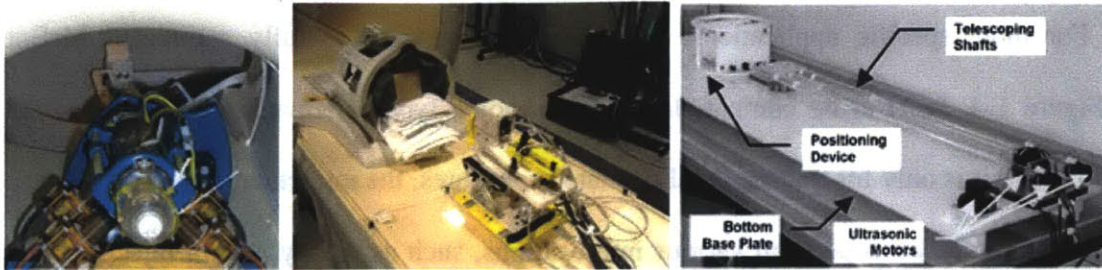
MRI compatible robots designed for single probe placement. Left: Mr. Bot from John Hopkins contains interchangeable end effector, allowing it to perform various interventions related to transperineal prostate procedures [13]. Middle: MRI compatible device for treating prostate brachytherapy developed at WPI. It is driven with a custom built MRI compatible motor controller [14]. Right: Robot designed at University of Minnesota for breast biopsy uses telescopic rods to actuate movement while keeping ultrasonic motor away from imaging bore [15].
